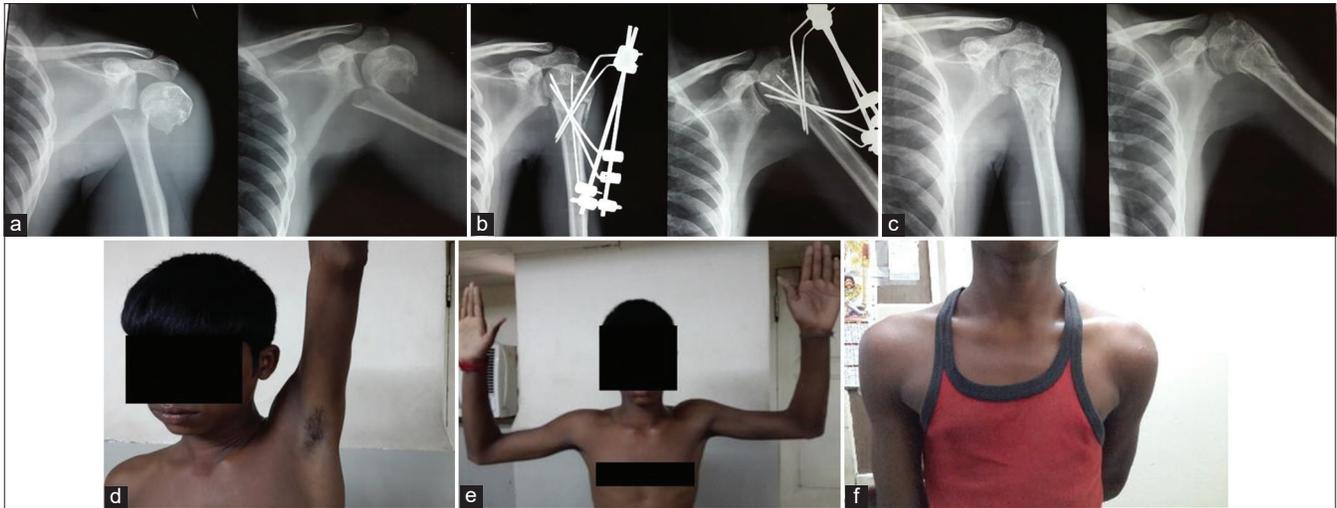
(a) Case 1-19 years male pre of X-ray AP/lat, (b) Case 1-6 weeks post-operative X-ray, (c) Case 1 – X-ray after implant removal, (d) Case 1 – final ROM elevation, (e) Case 1 – final ROM external rotation, (f) Case 1 – final ROM internal rotation
